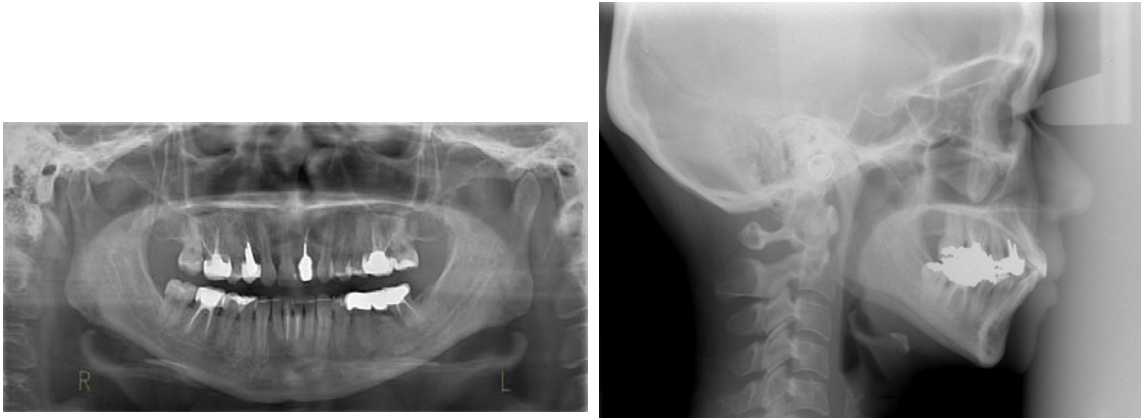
Final radiographic views: A, Panoramic view. B, Lateral cephalometric view.
